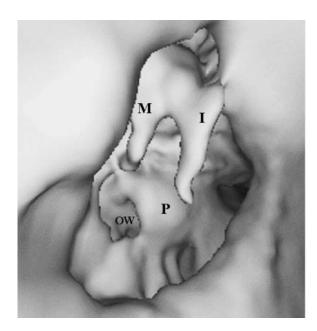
CT virtual endoscopy of the middle ear generated from a point of view located in the external auditory canal, shows the incus (I), malleus (M), promontory (P) and oval window (OW)
